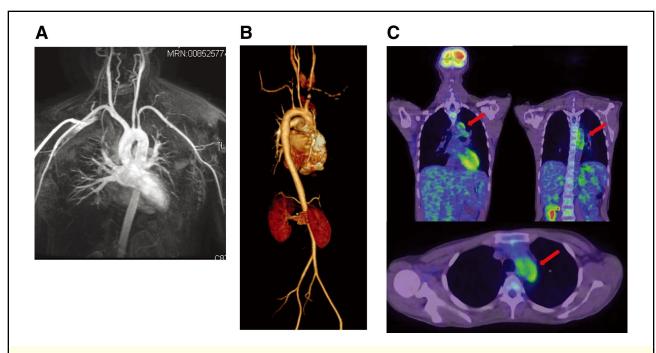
Representative case diagnosed by ¹⁸F-FDG PET/CT in the prestenotic stage. A 21-year-old woman experienced fever of unknown origin for 4 months. CRP and ESR levels were elevated to 8.73 mg/dl and 114 mm/h, respectively. MRA (A) and CTA (B) showed no abnormalities. However, since vascular bruit was heard over her right neck, ¹⁸F-FDG PET/CT (C) was performed and showed significant uptake in the aortic arch and descending aorta (arrows). On the basis of these findings, she was diagnosed with TA. CRP, C-reactive protein; CTA, computed tomography angiography; ESR, erythrocyte sedimentation rate; ¹⁸F-FDG PET/CT, ¹⁸F-fluorodeoxy-glucose positron emission tomography/computed tomography; MRA, magnetic resonance angiography; TA, Takayasu arteritis.
